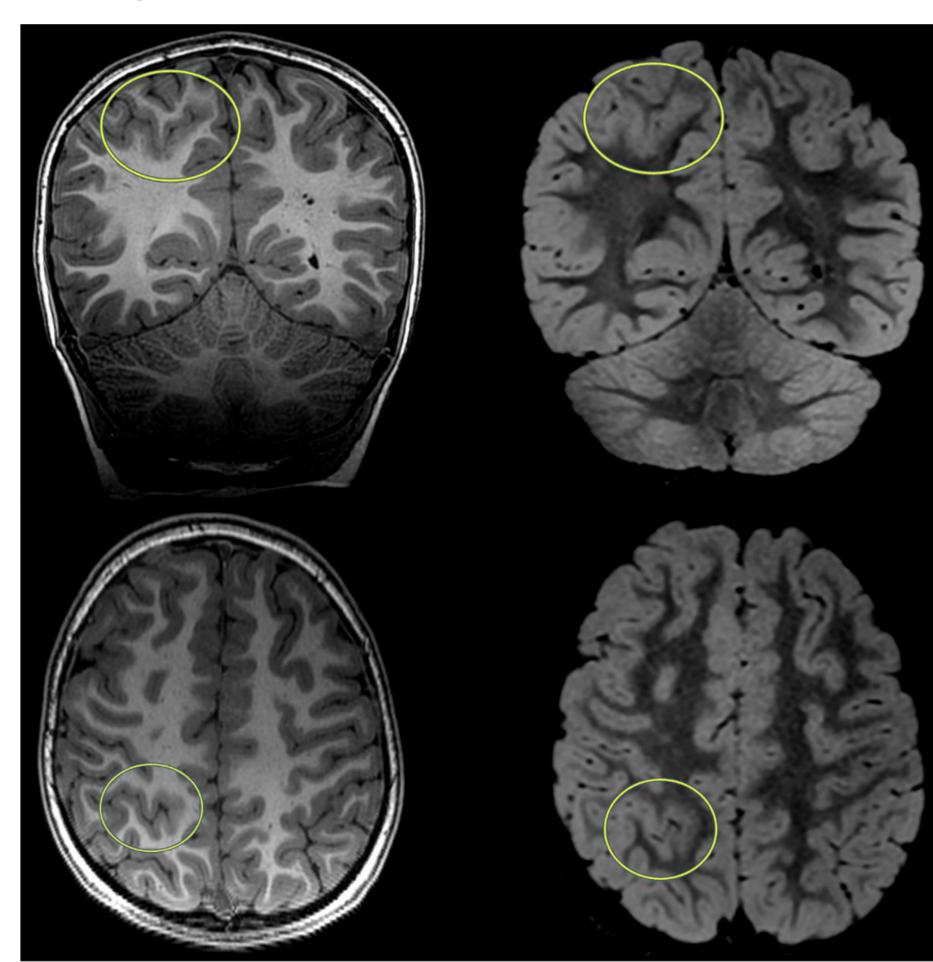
Figure E and F: T1 section. Figure G and H: Axial section in T1 T2/FLAIR. Deepening of a right precentral frontal cortical sulcus, associated with verticalization of the ipsilateral central sulcus, compared to contralateral. Alteration gray/white matter differentiation in right postcentral parietal topography.
